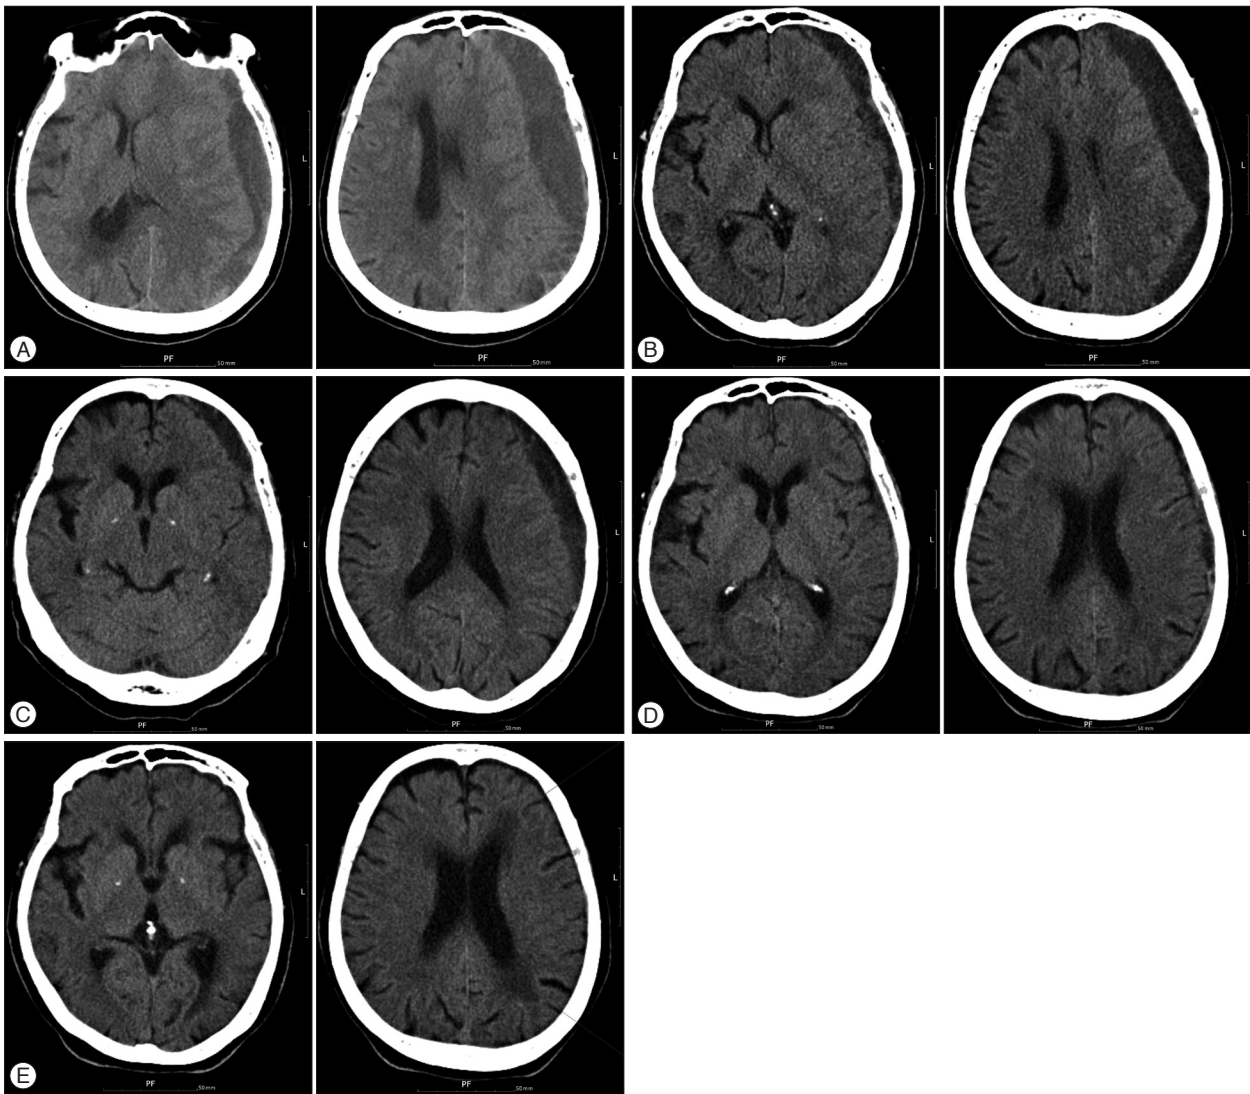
A : Initial brain CT scans showed thick crescent low density lesions in left fronto-temporo-parietal regions with midline shift. B : Follow-up CT scan 1 month later showed a decreased amount of subdural hematoma. C and D : Follow-up CT scan 2 and 3 months later showed gradual resolution of the hematoma. E : Follow-up CT scan 5 months later showed disappearance of the hematoma.
